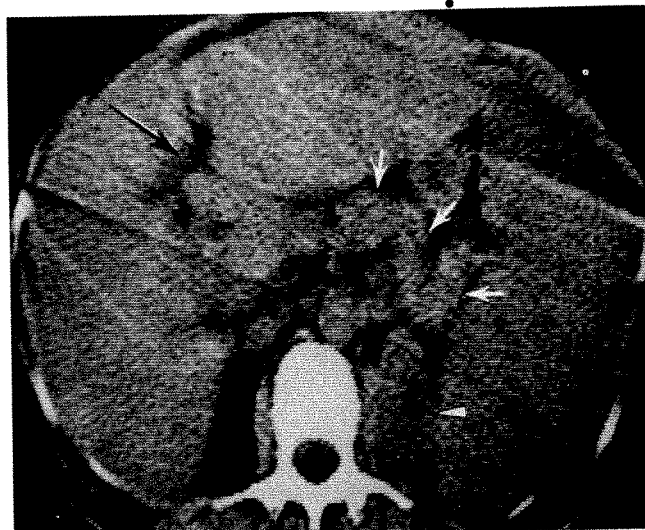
42-year-old woman with pruritis and jaundice and known systemic sarcoidosis. CT scan showing marked hepatosplenomegaly with compression of pancreas (white arrows) and kidney (white arrowhead). Some fat visible near porta hepatis (black arrow) but no evidence of dilated intrahepatic bile ducts. Percutaneous liver biopsy disclosed no caseating granulomas.
